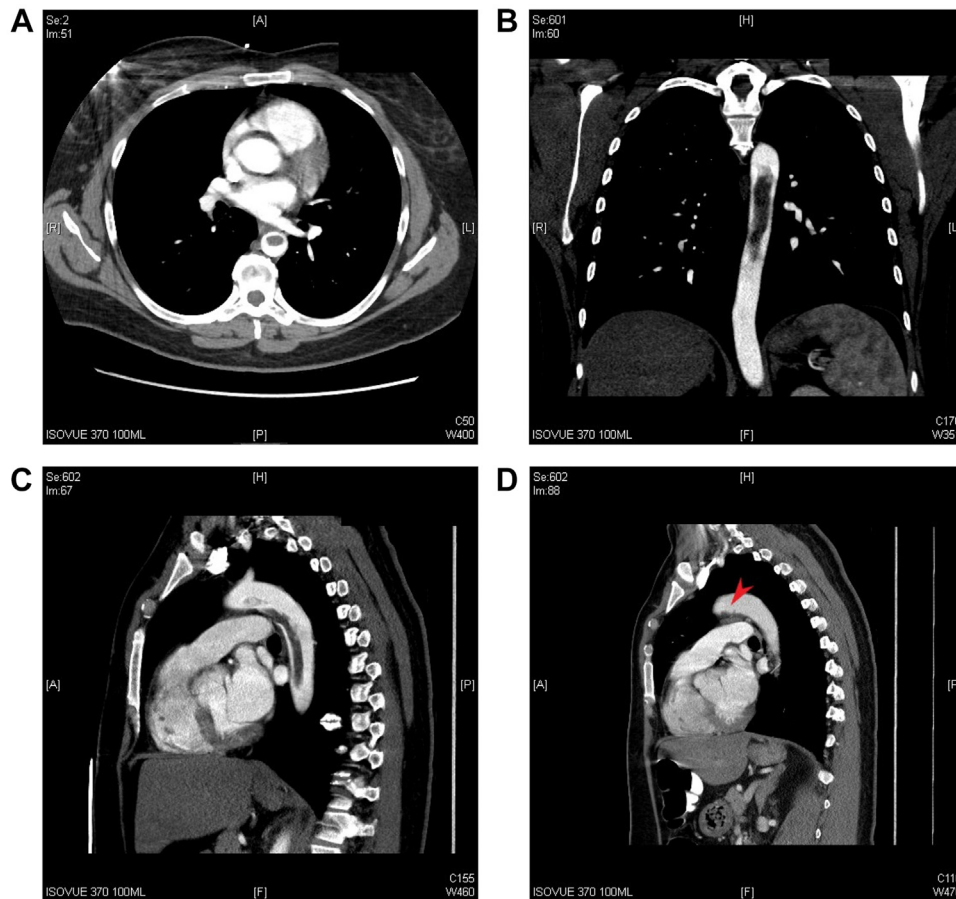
Computed tomography (CT) angiogram showing thrombus in the descending aorta with attachment site opposite left subclavian artery. (A) Axial. (B) Coronal. (C) Sagittal. (D) Sagittal 13-month postoperative with residual thickening proximal descending aorta (red arrow).
